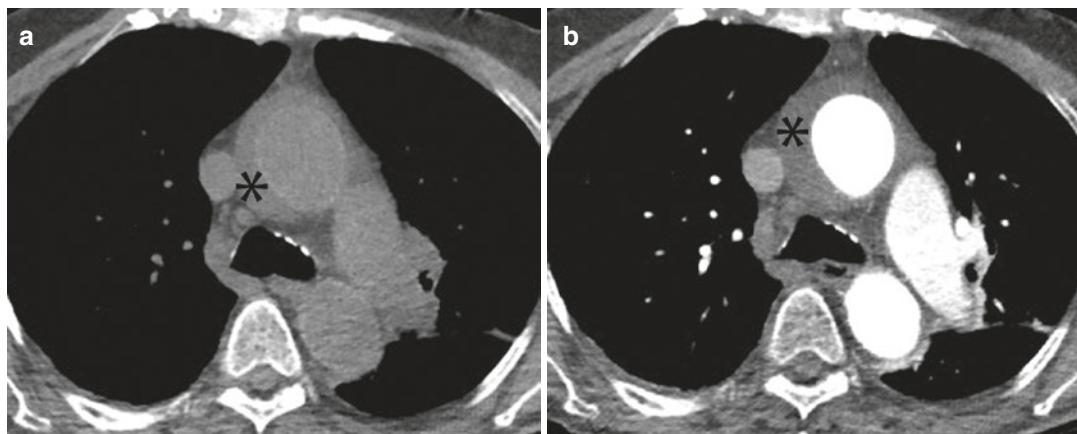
Pericardial recess mimicking intramural hematoma in an 87-year-old woman. Axial CT images without IV contrast (a) and with IV contrast (b) demonstrate fluid (*) around the ascending aorta. On the non-enhanced CT, the fluid measures below 20 HU (simple fluid) and is hypodense to the aorta. On the enhanced CT, the density
